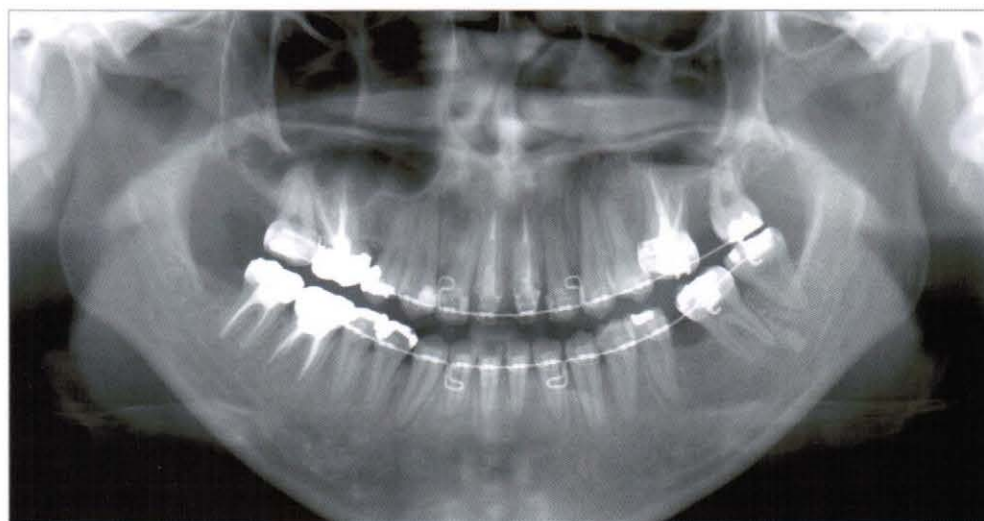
Panoramic radiograph taken after leveling (2005, 10,4)
